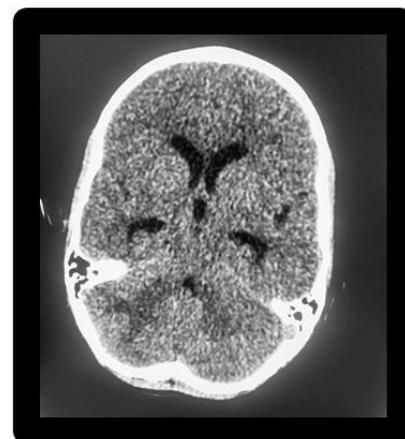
Brain CT scan. Helical acquisition without contrast injection. Ranges of right cerebellar hypodensities repressing V4 with ptosis of cerebellar tonsils.
